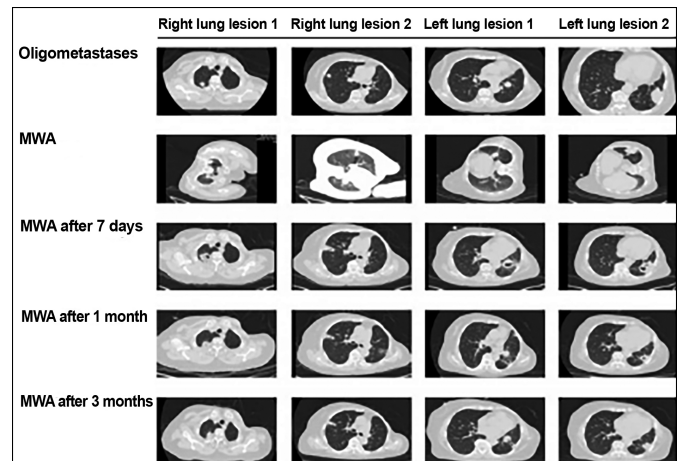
A 67-year-old female was found 4 nodules in lung. She had breast cancer and accepted surgery and chemotherapy. The pulmonary nodule was affirmed by mammary metastatic adenocarcinoma by biopsy pathology. The antenna was modified and repositioned according to imaging changes until the tumour was covered completely. The tumour has shrunken, fibrosis has developed and an irregular cavity has been formed from the CT image at 7 days, 1 month and 3 months after MWA.
